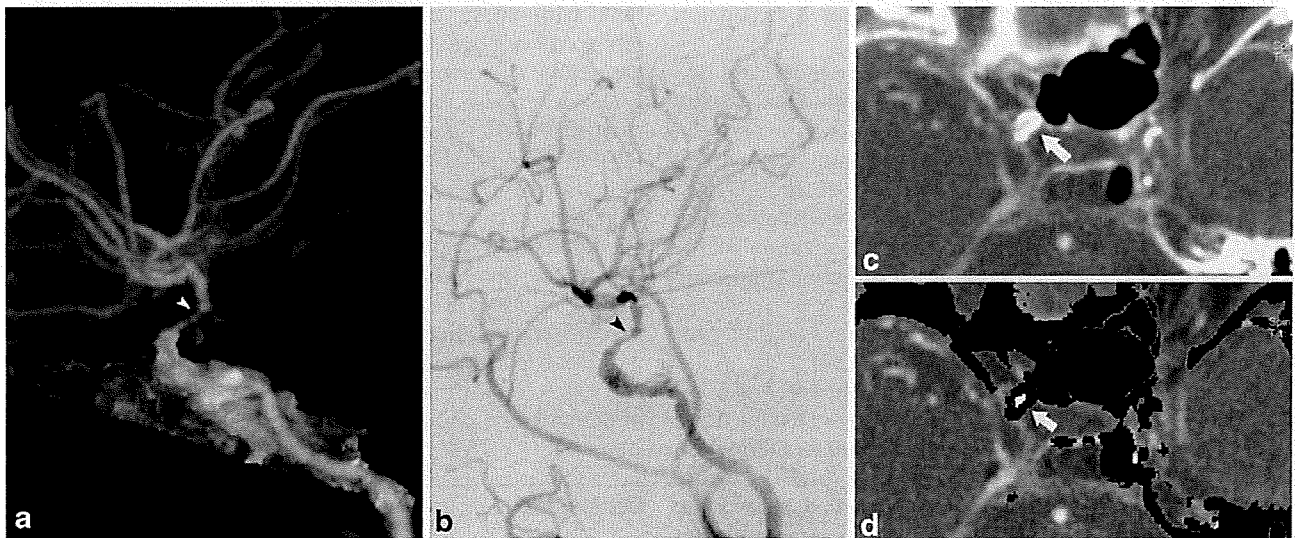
Right ICA severe stenosis of a 67-year-old female patient. C2 portion of ICA had severe stenosis (arrowhead) demonstrated by DE-BR-CTA (a) and DSA (b). The ophthalmic artery is not visualized by DE-BR-CTA or by DSA. CTA source images (c) show
